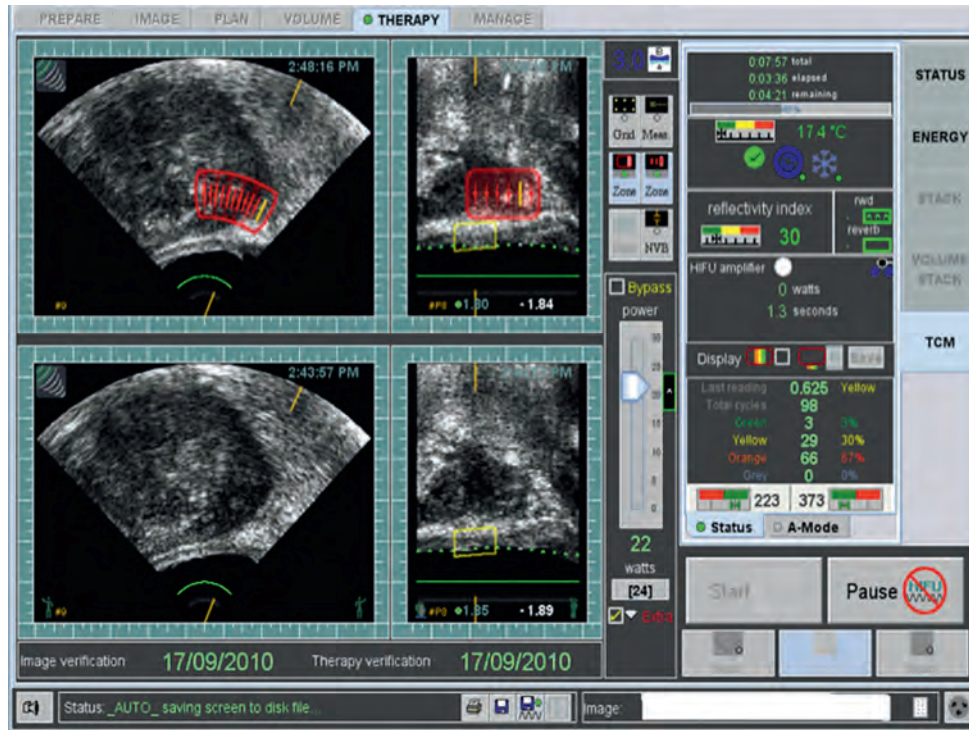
Screenshot of the Sonablate high-intensity focused ultrasound (HIFU) device. Treatment is delivered in blocks (red area). The lower two ultrasound images are pre-HIFU baseline images and allow a direct comparison. There are other safety features built into the device to prevent collateral damage. The power of each pulse can be controlled, giving fine control of the energy delivery into the prostate.
